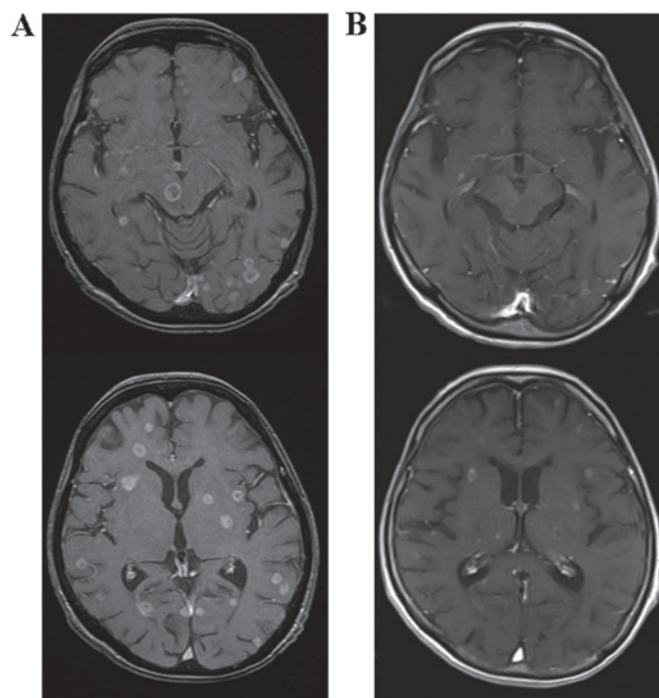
T1-weighted magnetic resonance images of the brain with gadolinium enhancement (A) prior to and (B) after treatment with osimertinib.
